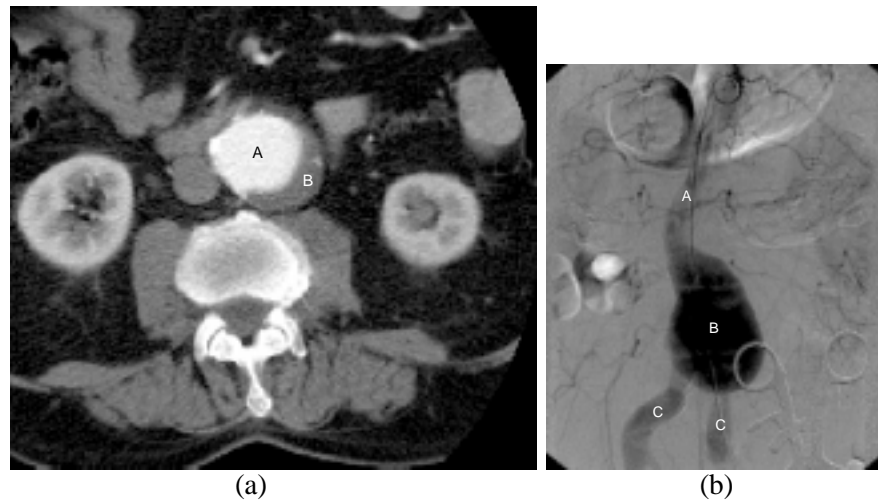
Images from aortic stenting procedure, (a) axial slice through pre-operative CT angiogram, showing (A) patent lumen and (B) thrombus in aneurysm, (b) intra-operative digital subtraction angiography image showing patent lumen in aorta (A), aneurysm (B) and iliac arteries (C).
